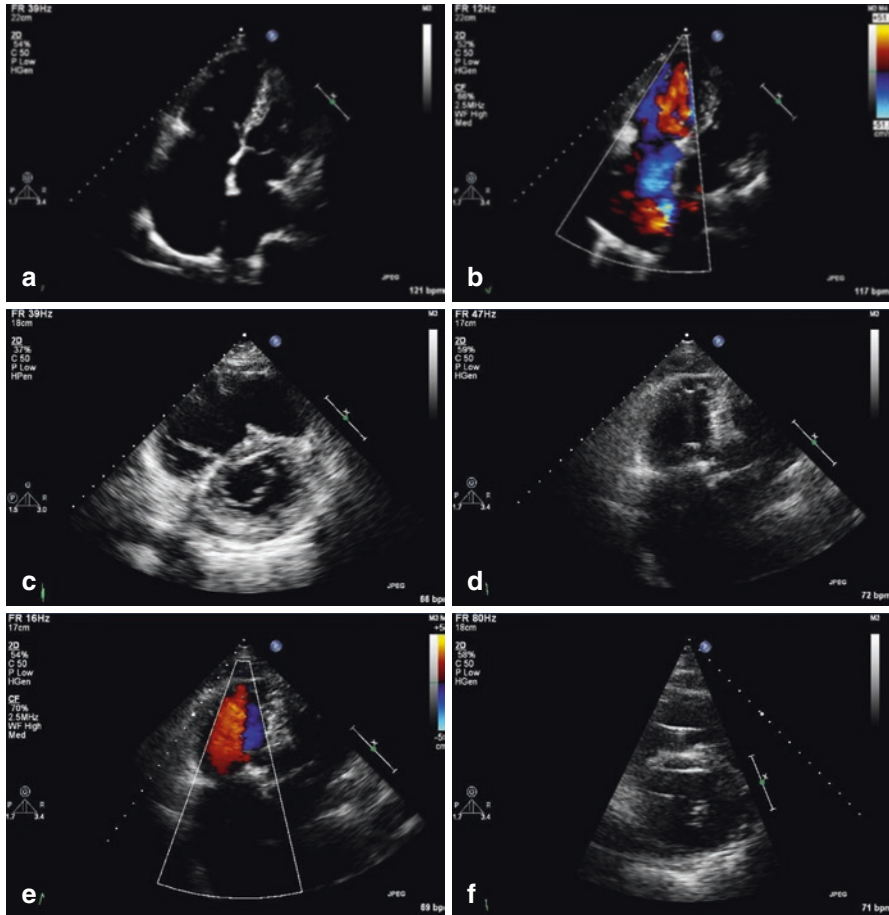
(a, b, and c, Movies S1, S2, and S3) Apical four chamber view demonstrating the severe dilated right ventricle and atrium with severe tricuspid regurgitation. The parasternal short-axis view shows enlarged right ventricle with diastolic collaps (“D-sign”) of the interventricular septum. (d, e and f, Movies S4, S5, and S6) Postoperative images, showing relatively reduced right ventricular size, with trace resting tricuspid regurgitation and disappearance of the “D-sign”
